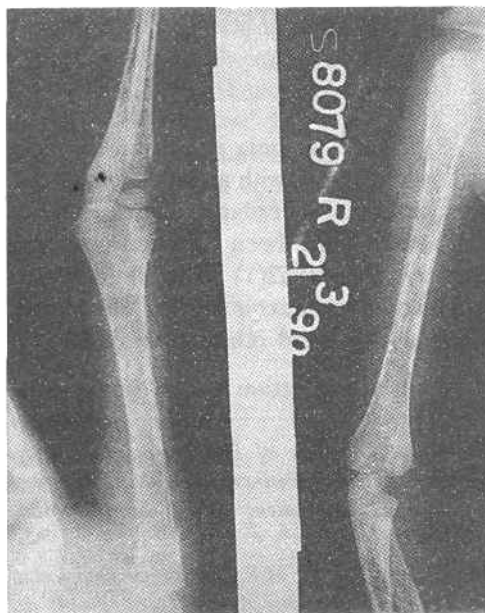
Radiograph of long bones showing intracortical symmetrical longitudinal fissuring at multiple sites.
